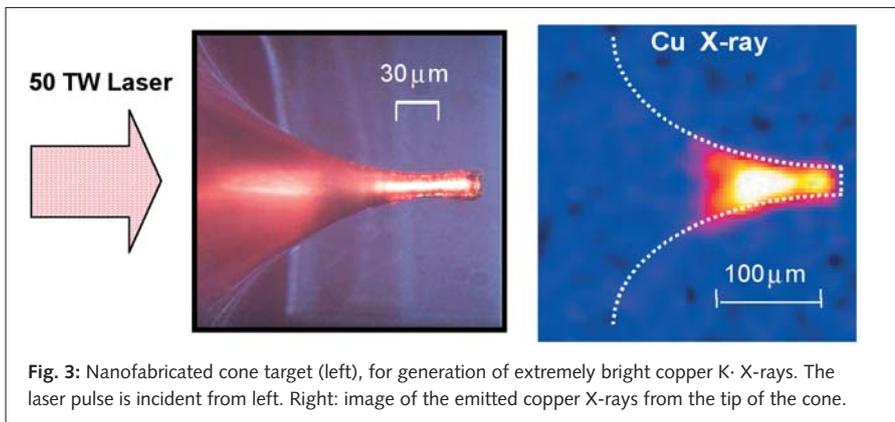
Nanofabricated cone target (left), for generation of extremely bright copper K \cdot X-rays. The laser pulse is incident from left. Right: image of the emitted copper X-rays from the tip of the cone.
